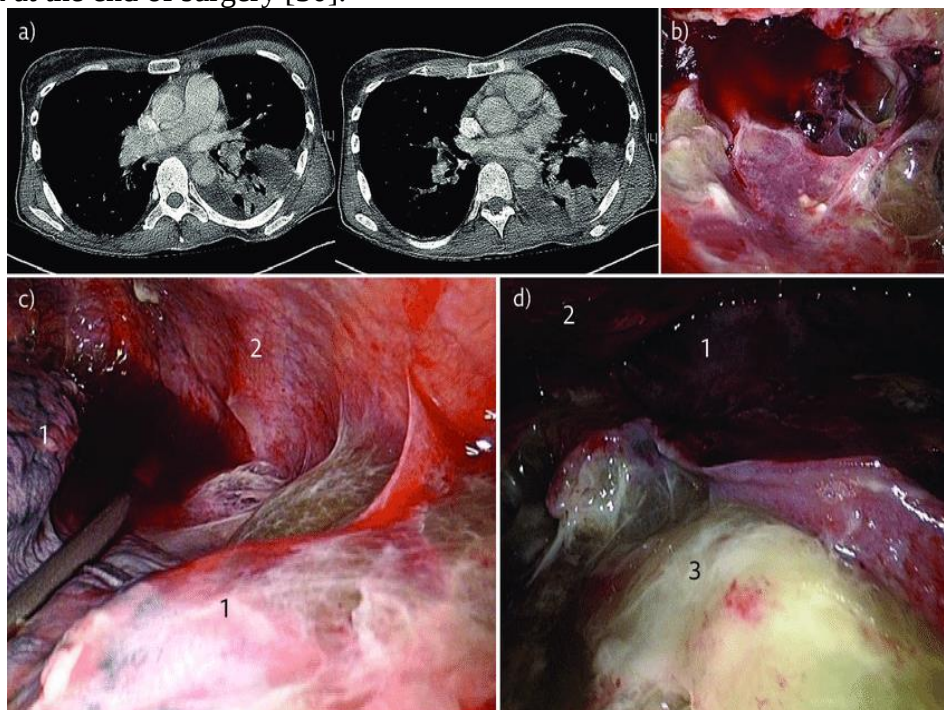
VATS decortication in pleural empyema stage II. a) Pre-operative CT of the thorax; b-d) operative views with multiple intrapleural loculations. 1: lung; 2: chest wall; 3: sub-pulmonary fibrin collection. [29].
